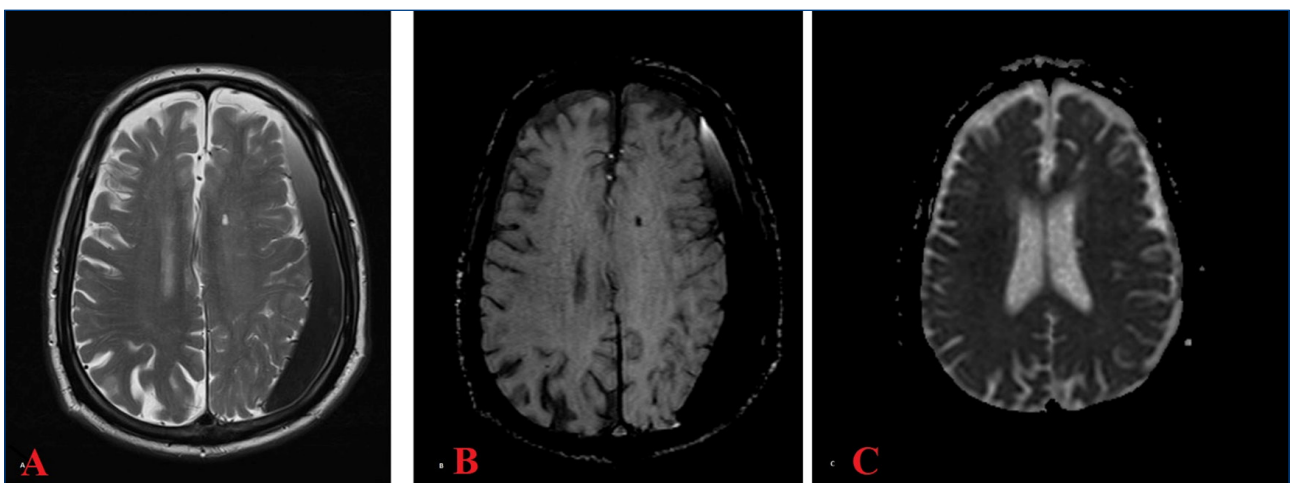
The patient, who was treated for acute stroke two years ago, shows chronic ischemic changes in the follow-up diffusion MRI. Specifically, Figure 2A reveals hyperintense areas on ADC, and Figure 2B shows hypointense areas on DWI. The images also display a chronic subdural hematoma on the same side as the stroke sequelae, causing cortical compression. Figure 2C - In the MRI imaging taken 15 months post-surgery, the chronic ischemic changes persist; however, the chronic subdural hematoma has completely resolved, and the brain parenchyma appears expanded.
